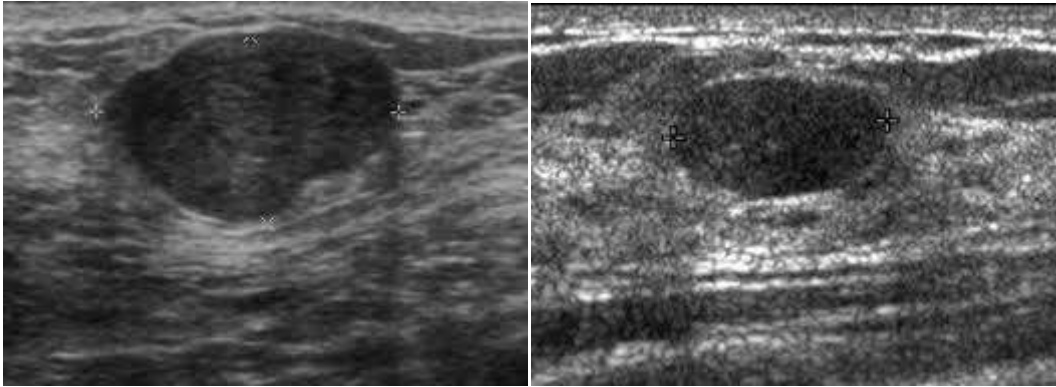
Ultrasound image of benign mass, reviewed a well circumscribed benign fibroadenoma.
